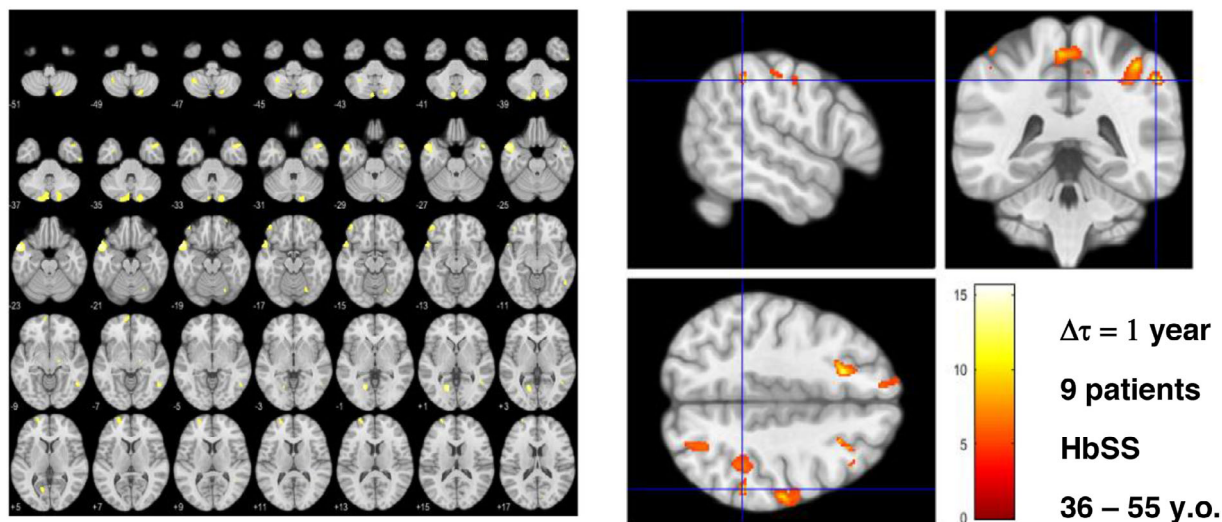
In nine SS patients, morphometric analysis after 1 year of the first MRI revealed progressive atrophy, especially in the right temporal lobe, frontal lobes and basal ganglia (colored areas). All patients had a sickle cell anemia diagnosis (SS).
